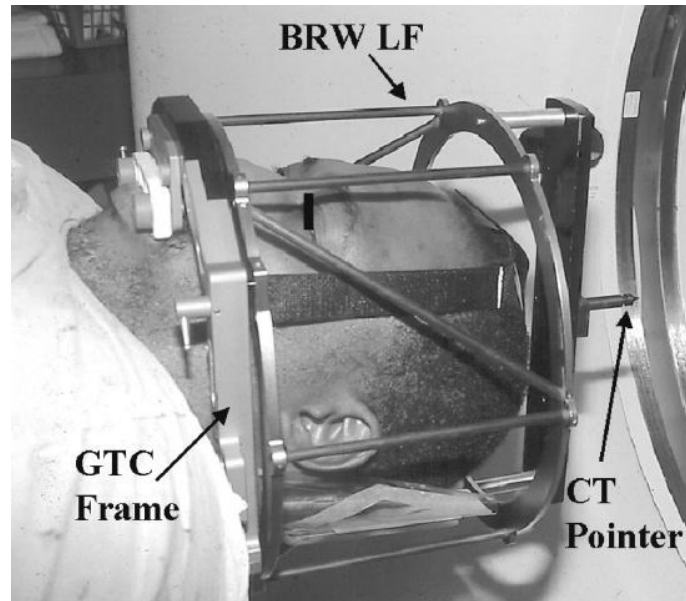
Position of the patient during the planning CT scan using GTC frame and BRW localiser
